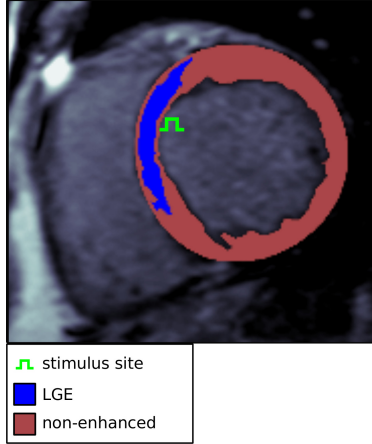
Source late gadolinium enhanced MRI with location of stimulus site and enhanced and non-enhanced areas.
